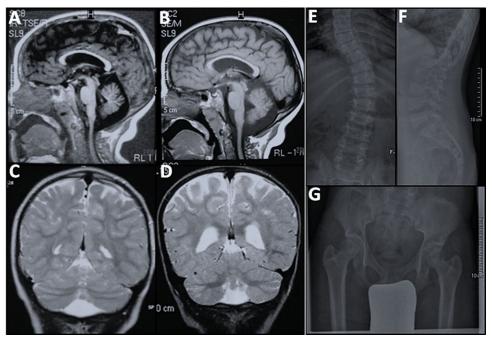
Neuroimaging and radiographic studies of the patients with RPL10 mutation. A and B: Brain MRI scan of affected individuals III:1 and III:2: mid-sagittal T1-weighted image shows an overall size reduction of the cerebellum predominant in the vermis and enlarged cerebral ventricles. C and D: Brainstem and cerebral cortex are normal. Coronal T2-weighted images showing vermis hypoplasia and ventricular dilatation, more pronounced in patient III:2. E and F: Radiograph of index patient III:1 thorax and lumbar vertebrae showing platispondily and scoliosis. G: The pelvis radiograph shows epiphyseal dysplasia of the femoral head and neck.
